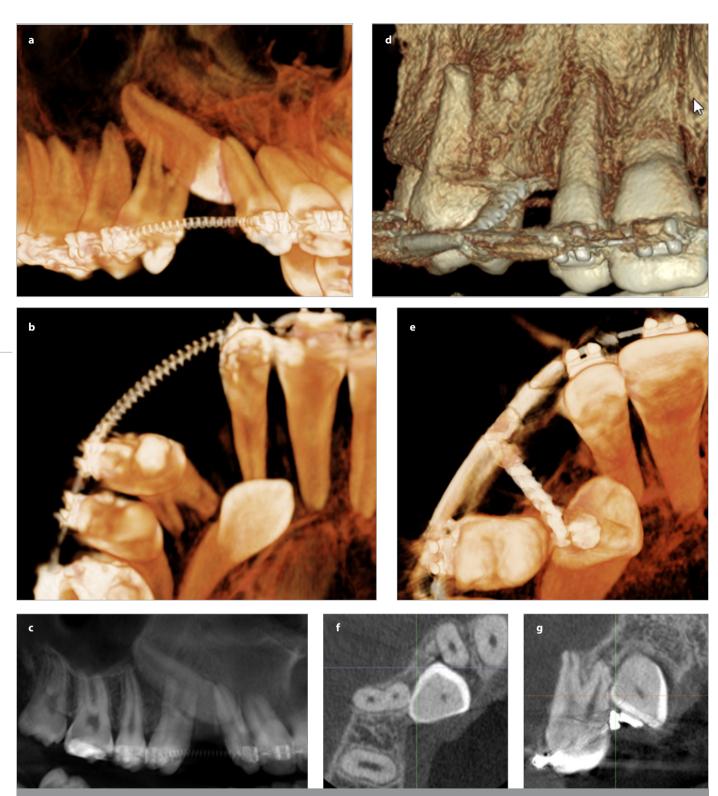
a-g. Inadequate orthodontic traction. Cone beam computer tomography (CBCT) images taken before orthodontic traction (T1) and after nine months of orthodontic traction when the patient was referred (T2), (a) and (b) 3D reconstruction at T1, (c) part of the CBCT panoramic reconstruction at T1, (d) and (e) 3D reconstruction at T2, (f) axial slice at T2, (g) coronal slice at T2.
